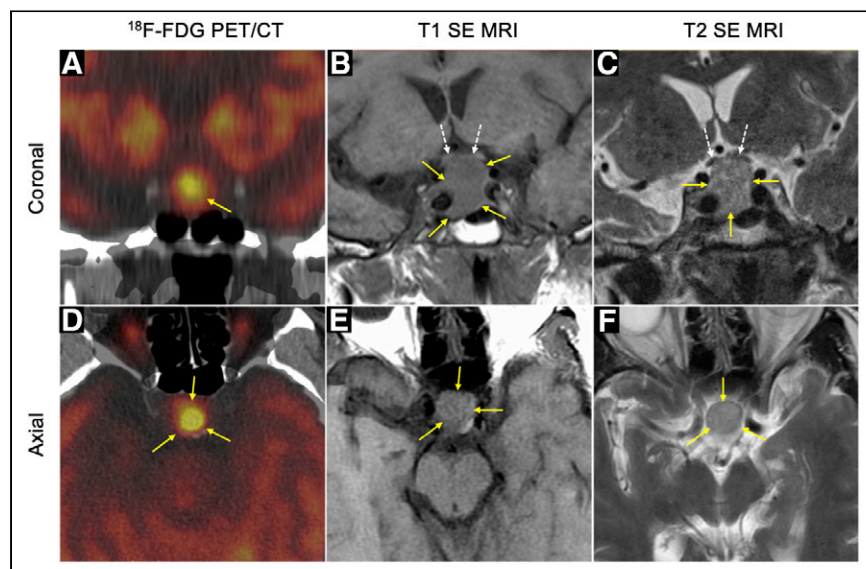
Nonfunctioning pituitary macroadenoma incidentally detected on ^{18}F -FDG PET/CT. (A and D) Coronal and axial PET/CT demonstrating focal ^{18}F -FDG sella uptake. (B, C, E, and F) Coronal and axial T1 and T2 SE MRI confirms a macroadenoma (yellow arrows) with suprasellar extension and optic chiasm displacement/compression (dotted white arrows). SE = spin echo.
